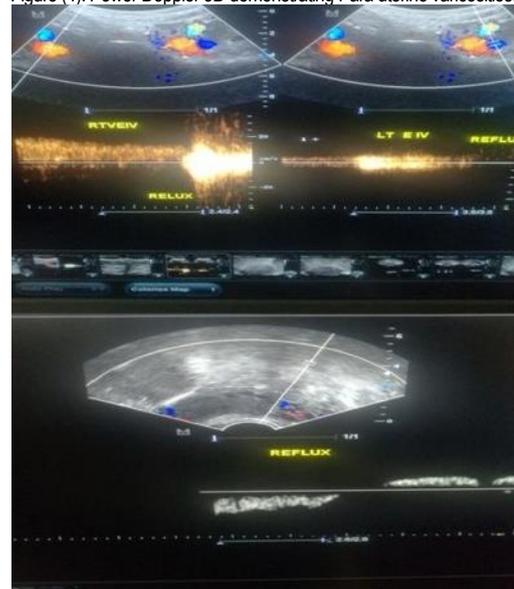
Transvaginal color Doppler study showing bilateral dilated ovarian veins with reflux.
